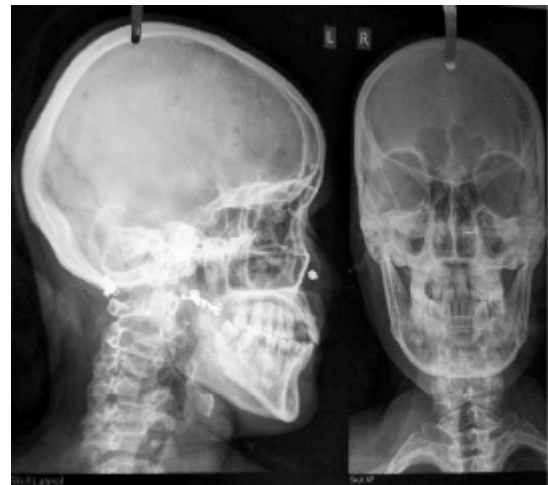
X-ray Skull AP/Lateral: Well Defined Small Rounded Punched Out Radiolucent Areas Noted Diffusely Involving the Calvarium
